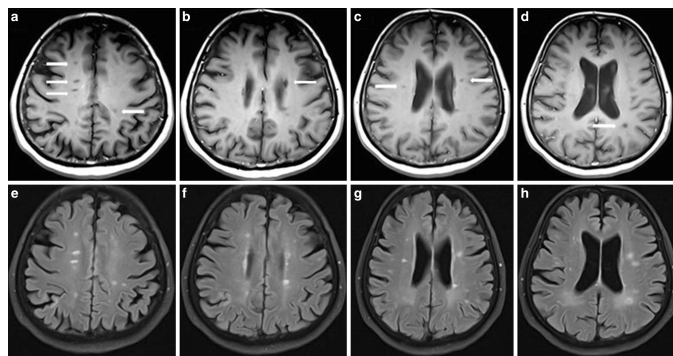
Examples of black holes indicated by white arrows in four PPMS patients. Top row: Axial T1-weighted spin-echo images. Bottom row: Axial fluid attenuated inversion recovery (FLAIR) images with corresponding hyperintense lesions in the same locations. Image source: (Siger 2022), distributed under Creative Commons Attribution 4.0 International License
